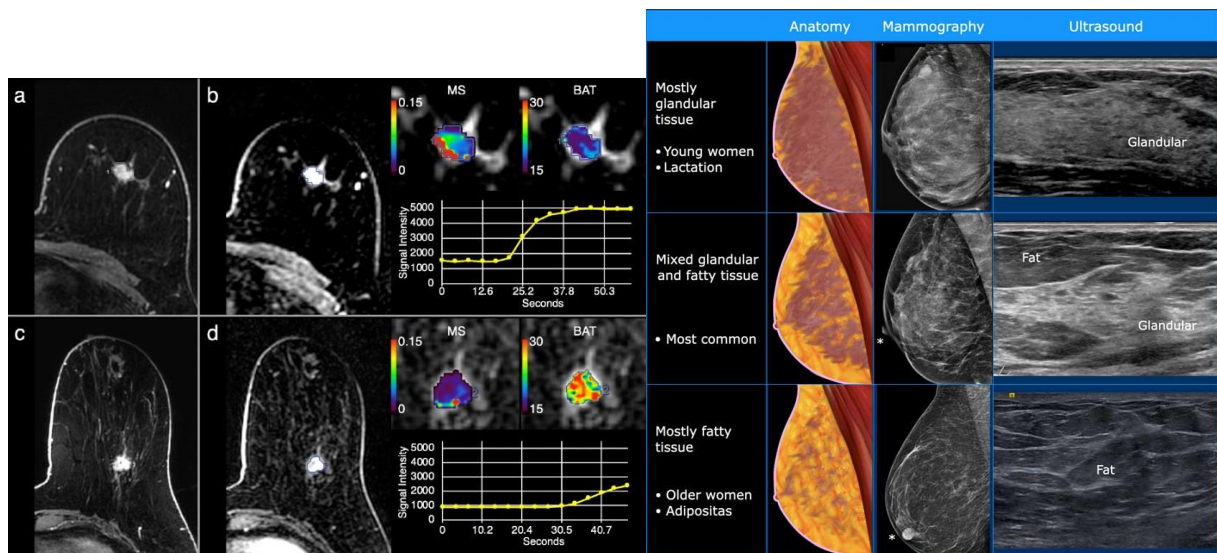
Comparative presentation of the diagnostic capabilities of mammography, ultrasonography, and dynamic contrast-enhanced magnetic resonance imaging (MRI) depending on breast tissue composition and tumor characteristics. In dense glandular breast tissue, the sensitivity of mammography decreases, whereas ultrasonography and MRI provide additional diagnostic value. Dynamic contrast-enhanced MRI demonstrates rapid signal intensity increase and subsequent “wash-out” kinetics, which are characteristic features of malignant lesions.
